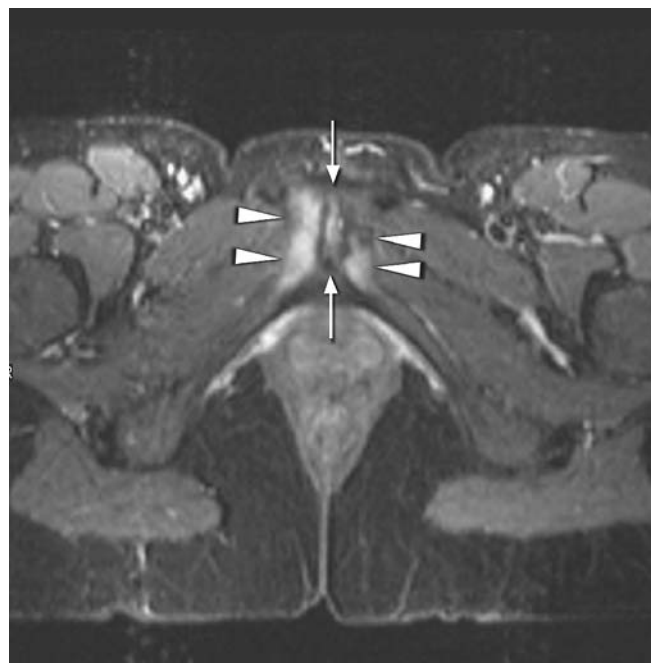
MR imaging findings in osteitis pubis. On the axial STIR image of the pelvis the bone marrow signal abnormalities on each side of the symphysis (*arrowheads*) and increased signal within the symphysis (*arrows*) are present
